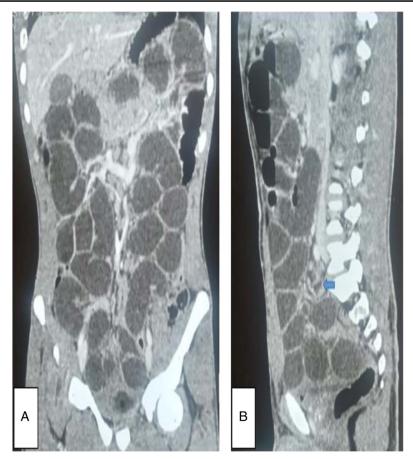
Portal phase computed tomography images showing distension of the small intestine (A) and a transitional zone next to L5-S1 (B, blue arrow).
